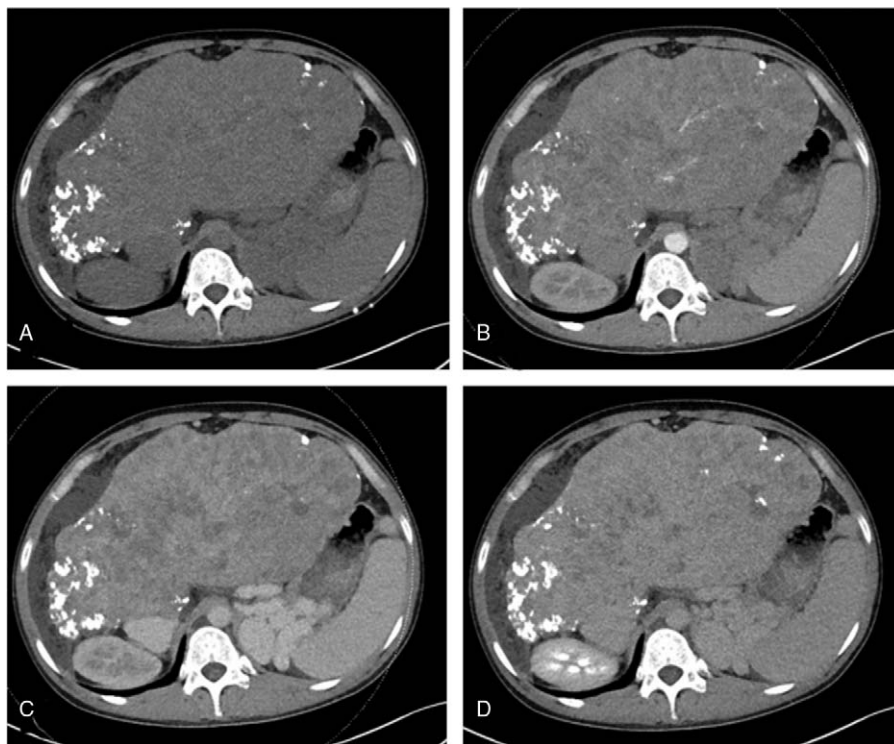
Contrast enhanced computed tomography scan of the abdomen showing multifocal lesions enhanced progressively during the arterial phase, portal phase, and delayed phase.
